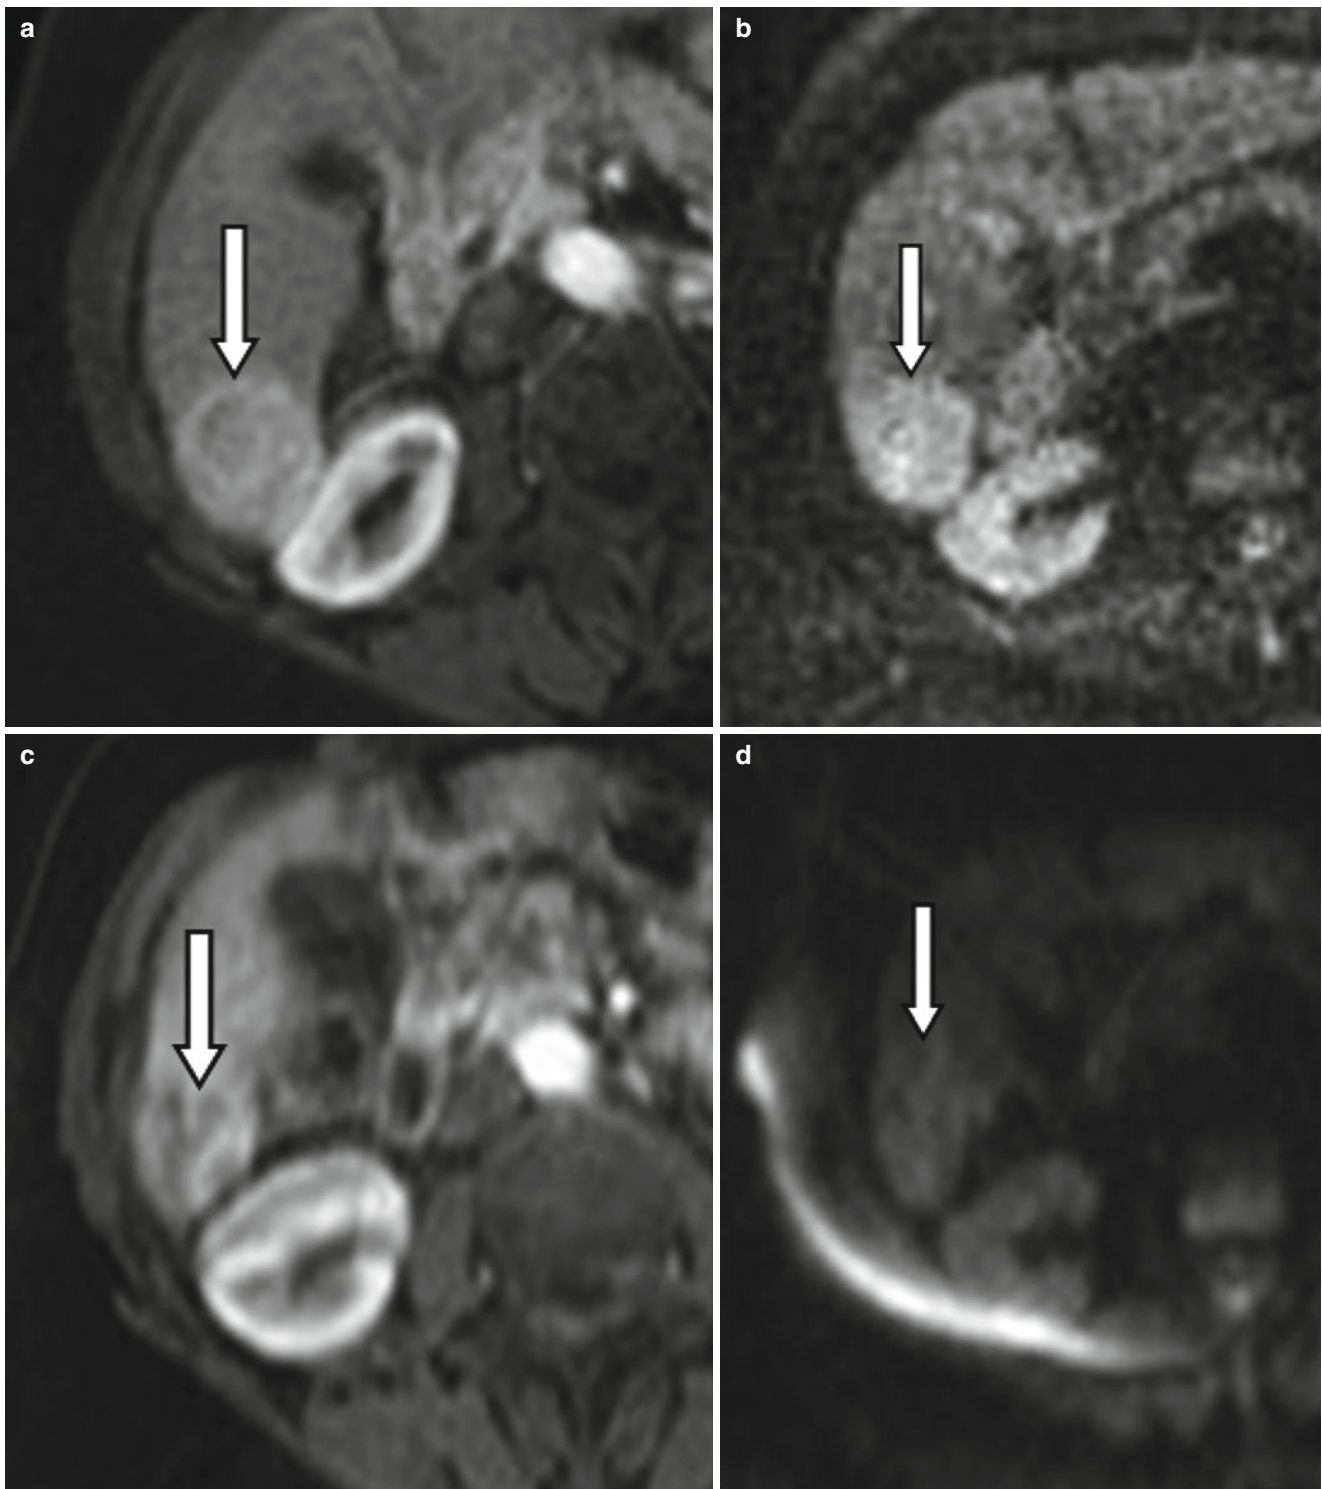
A 65-year-old female patient with unresectable HCC. The lesion in segment VI of the liver (*arrow*) was treated with radioembolization. Before treatment the lesion is hyperintense on contrast-enhanced fat-saturated gradient echo imaging indicating enhancement (a) and hyperintense on diffusion-weighted (b800) MR images indicating restricted diffusion (b). After treatment, necrosis is evident by loss of internal enhancement (c), and improving restricted diffusion (d)
